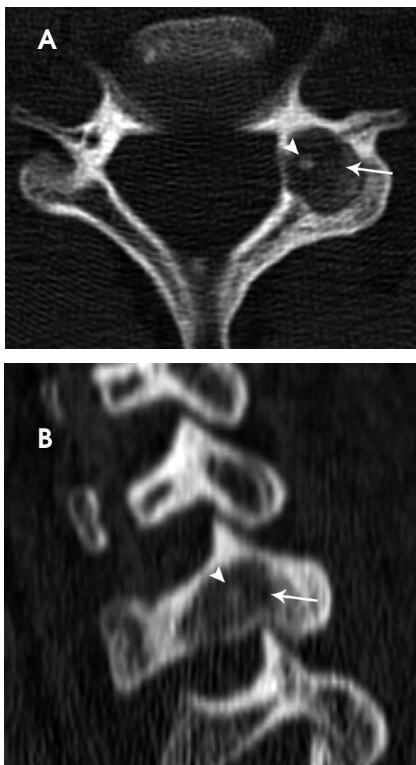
Axial bone window CT section through the C6 vertebra (A) and sagittal reformation (B) show an expansile, lytic lesion (white arrow) with sclerotic nidus (arrowhead), typical of osteoid osteoma.
